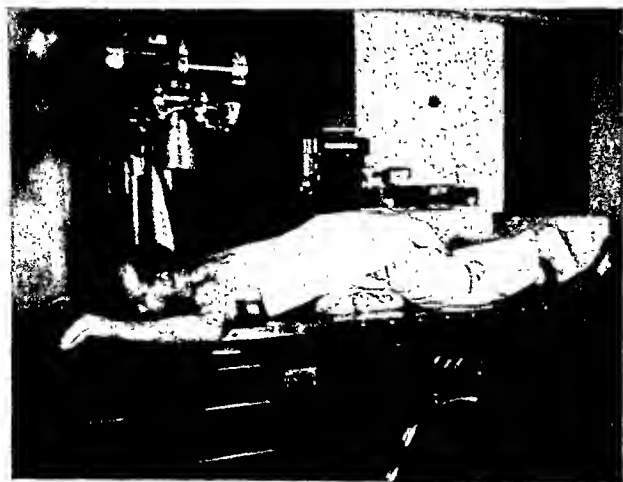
Overhead tube, Bucky and patient in position for roentgenography. The base of the occiput and the inferior border of the mandible are in a plane perpendicular to the table top.
